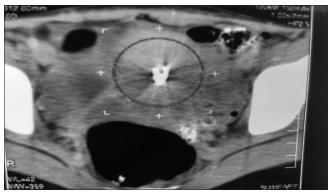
CT pelvis showing the metallic foreign body
